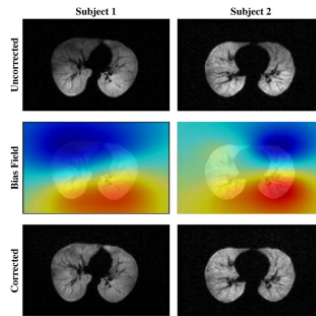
Example of a bias field correction on a lung MRI. Top: uncorrected images. Middle: estimated bias fields. Bottom: corrected images. Figure from [67].
